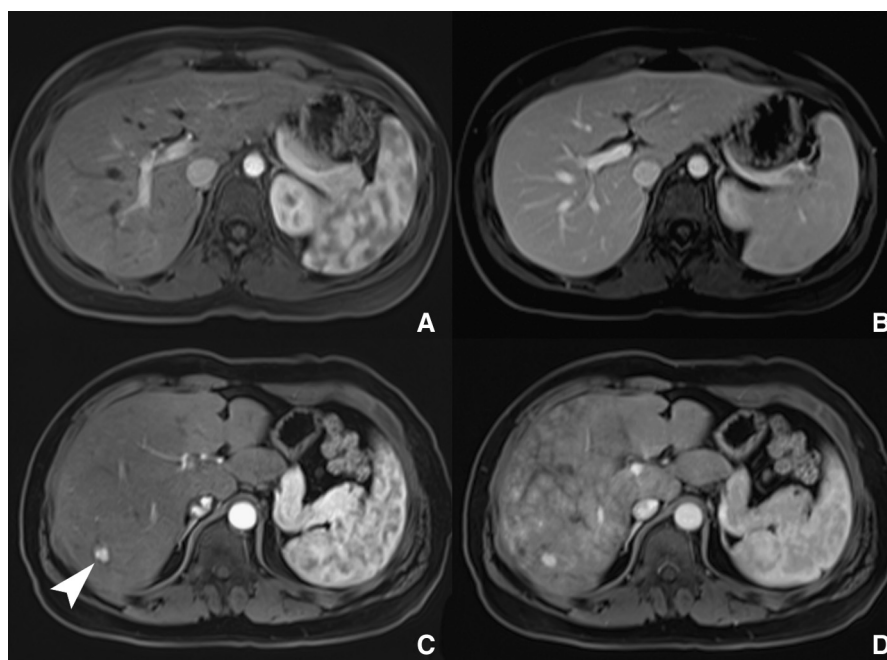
A, Axial T1-weighted gradient echo sequence arterial phase postcontrast showing normal hepatic parenchyma with homogeneous enhancement. Note the characteristic zebra pattern within the spleen. B, Venous phase, also showing homogeneous enhancement in normal liver. C, Arterial phase enhancement in a patient after Fontan surgery with a single arterially enhancing lesion in segment 6. D, Venous phase in the same patient showing the characteristic cloud-like enhancement of venous congestion.
